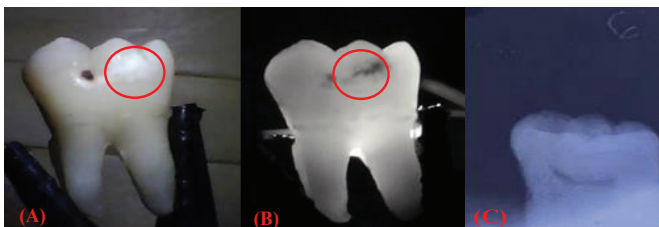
Sample 2 under visible light (A), NIR light (B), and X-rays (C).
